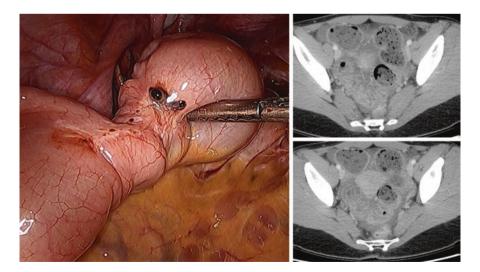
Laparoscopic and magnetic resonance imaging view of bowel endometriosis
